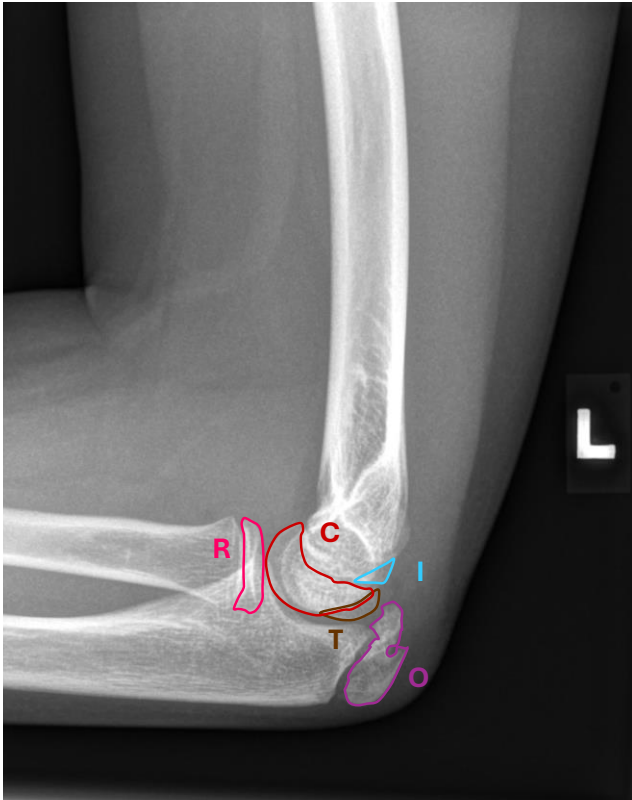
Normal radiographs of the elbow in a 11-year-old child. The ossification centers are annotated. (lat. view).
